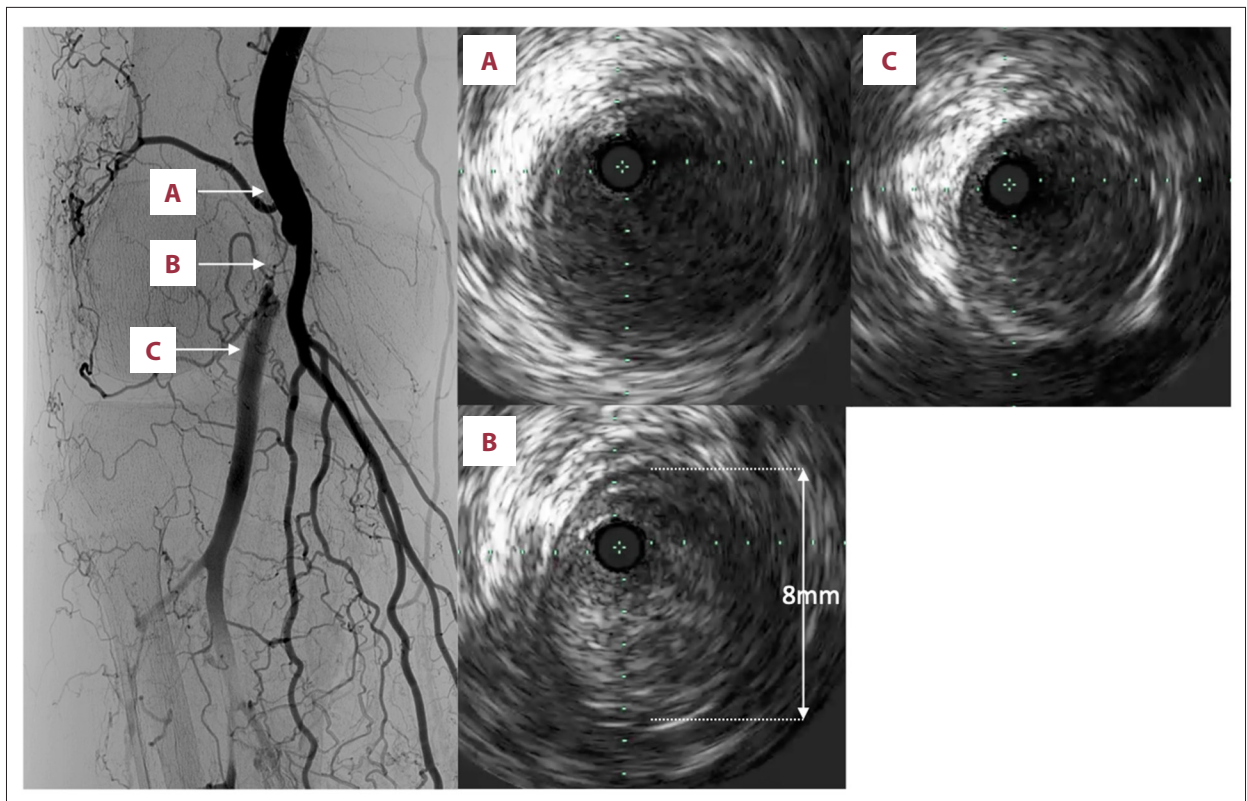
Intravascular ultrasound. (A) A proximal reference segment. (B) Intravascular ultrasound examination of the target lesion showed an isoechoic-to-hyperechoic lesion with no backward signal attenuation and no dense calcium. The diameter of the popliteal artery was 8 mm. (C) A distal reference segment.
